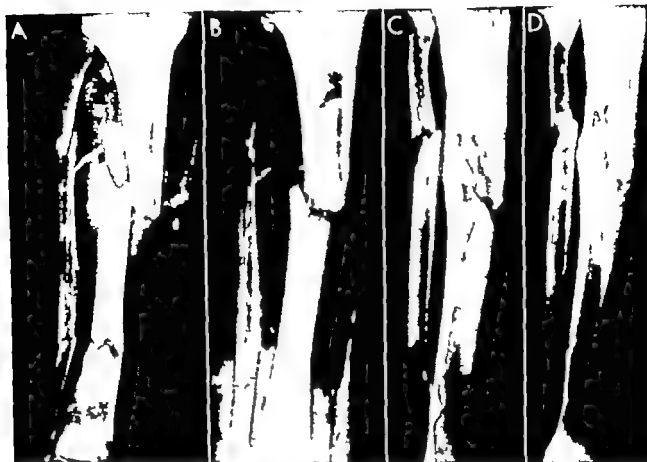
A, comminuted segmental open fracture of tibia and fibula immediately after injury. Note that the distal fracture shows minimal displacement and is relatively stable. The proximal fracture is comminuted, displaced and unstable. B, 19 days after closed reduction and skeletal traction to maintain length and alignment. Distraction has occurred at the proximal fracture line and delay in union may be predicted. C, 3 months after injury. The distal fracture is healing satisfactorily but there is delay in healing of the proximal fracture. Note the cortical fragments not yet revascularized. The clinical and x-ray evidence of delay in union prompted the use of autogenous iliac onlay grafts. D, 10 months after injury, 7 months after bone grafting, union satisfactory. Excellent end-result. A₁E₁F₁.
